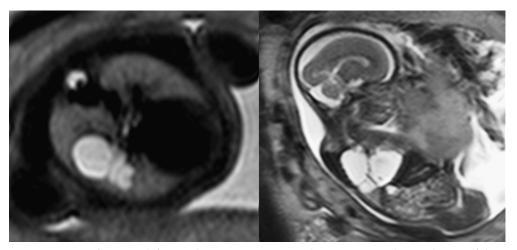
MRI of a 29-week fetus with macrocystic CCAM. The transverse and sagittal views of the fetal thorax show hyperintensive cystic lesions in the right lung.
